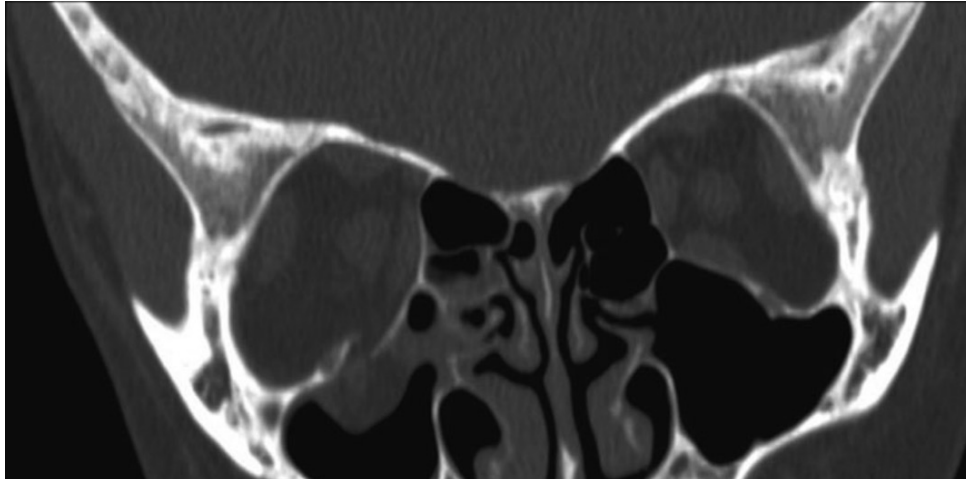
Coronal CT showing right orbital trapdoor fracture with displacement of inferior rectus muscle through fracture. Note the rounded shape of the muscle belly compared with the unaffected eye. *From Morrow BT, et al. Evidence-based medicine: Mandible fractures. Plast Reconstr Surg . 2014 Dec;134(6):1381-1390.*
